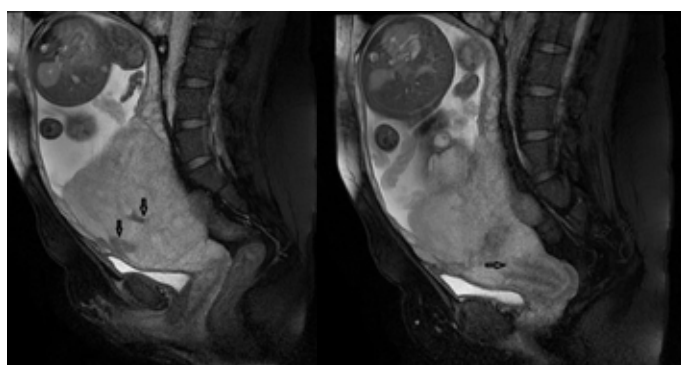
A 32-year-old female patient with history of LSCS, presenting with ultrasound consistent with placenta percreta: note a. (left) the intraplacental dark bands (arrows); and b. (right) low lying placenta, covering the internal os of the cervix (arrow).
